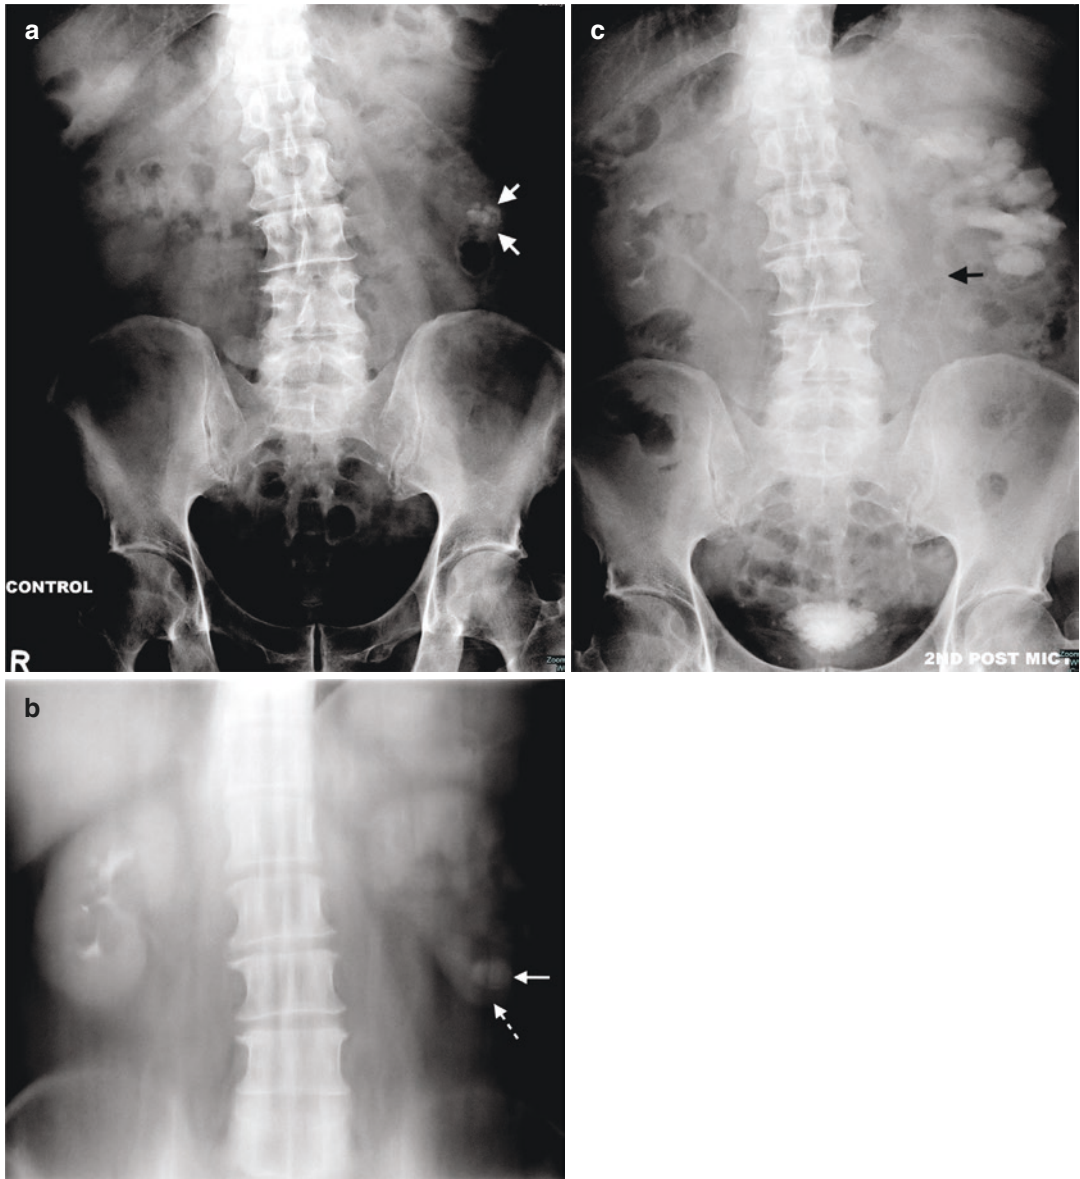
Left renal and ureteric tuberculosis. (a) IVU control radiograph shows a cluster of calcifications projected over the lower pole of the left kidney (arrows). (b) Coned renal tomogram, obtained after intravenous contrast administration, shows contrast opacification of the right pelvicalyceal system with none seen in the left pelvicalyceal system. The left lower renal parenchyma is thinned (dotted arrow), and the calculi (solid arrow) seen on the control radiograph are located in the lower pole calyces.
